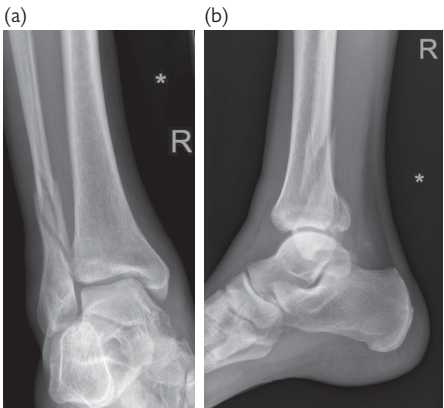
AP and lateral ankle X-rays showing a (Weber C) fracture of the distal fibula plus a fracture of the posterior distal tibia, but no obvious talar shift.
